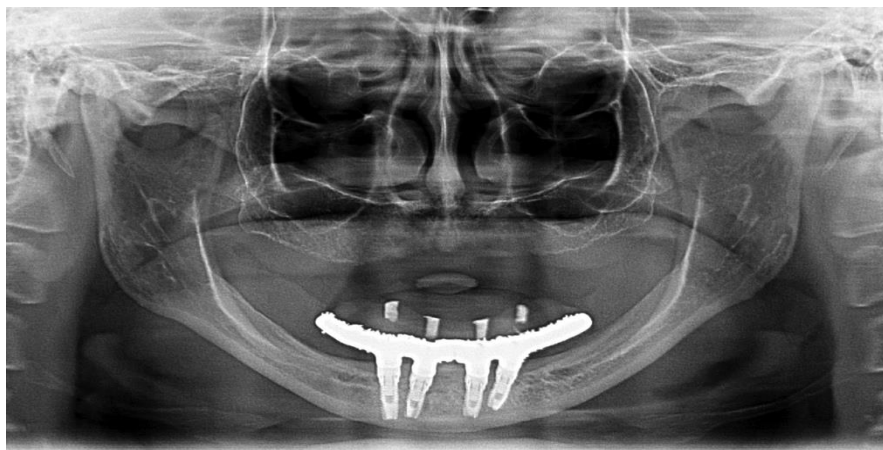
Panoramic X-ray immediately after installation of the prosthesis.
